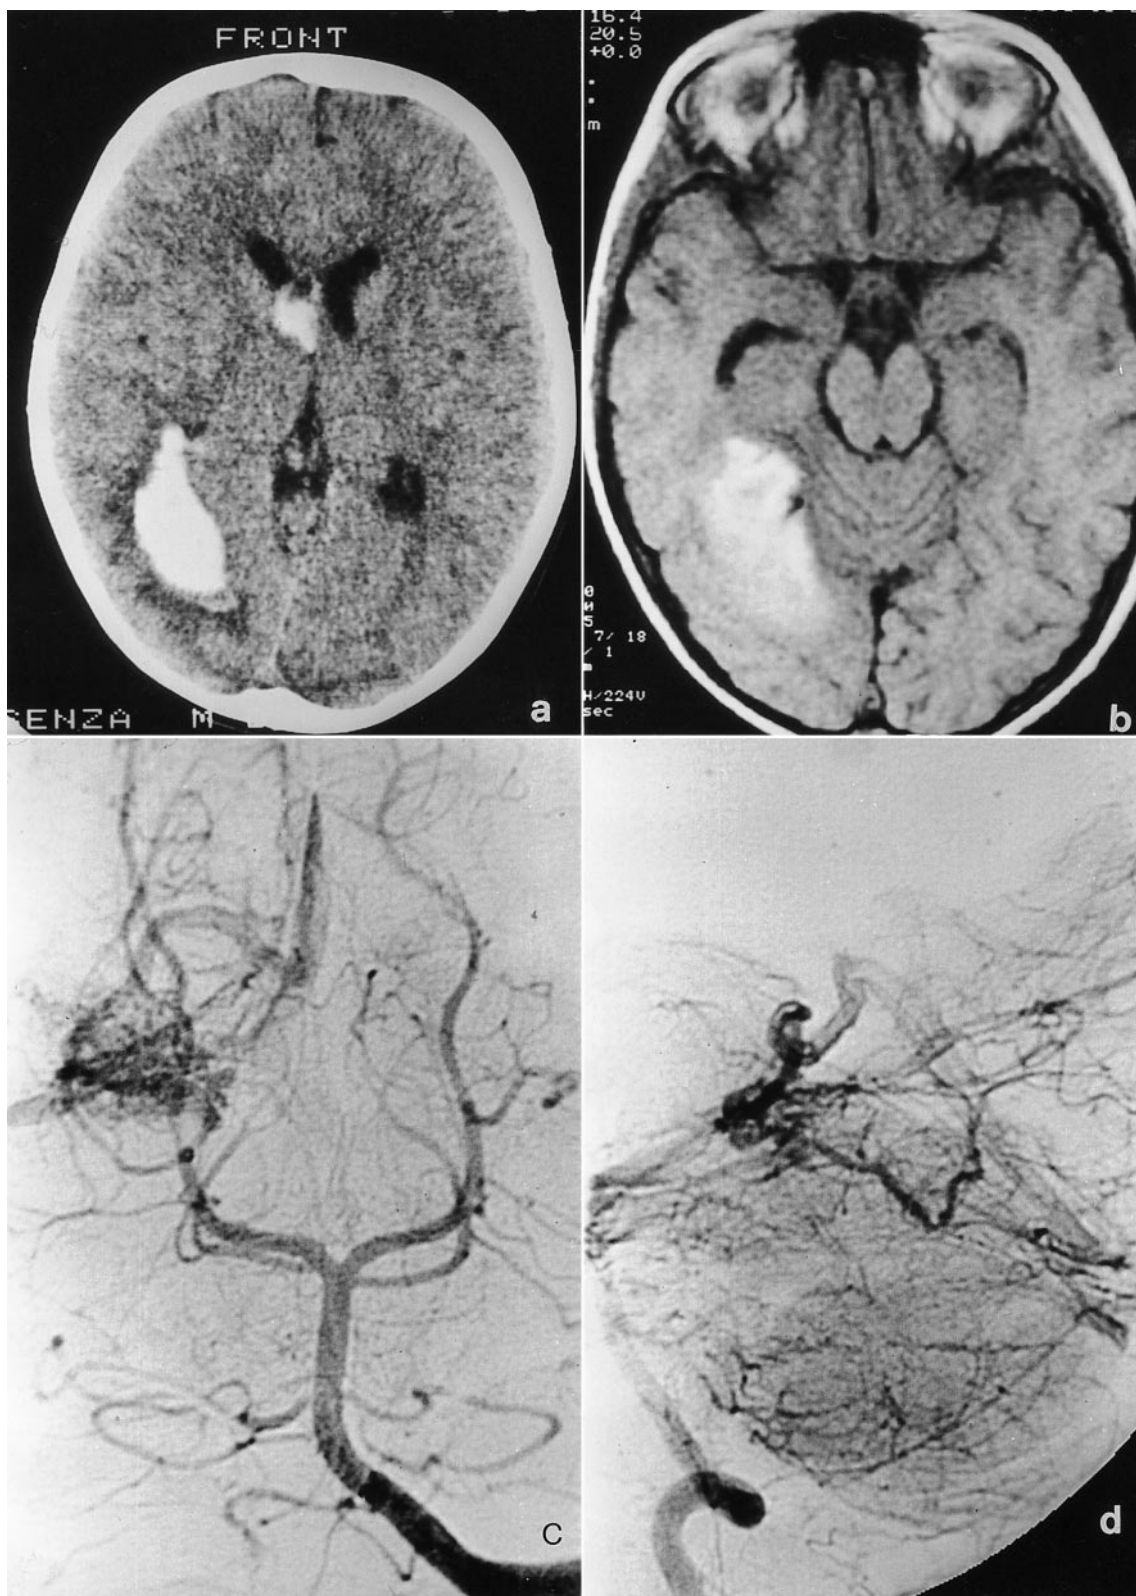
CT and MRI scans showing a right parieto-occipital intracranial haemorrhage (5a, 5b) with ventricular bleeding; vertebral angiogram of the same patient in the AP and LL views showing a right posterior temporal AVM with afferents from the posterior choroïdal and posterior cerebral arteries (5c, 5d).
